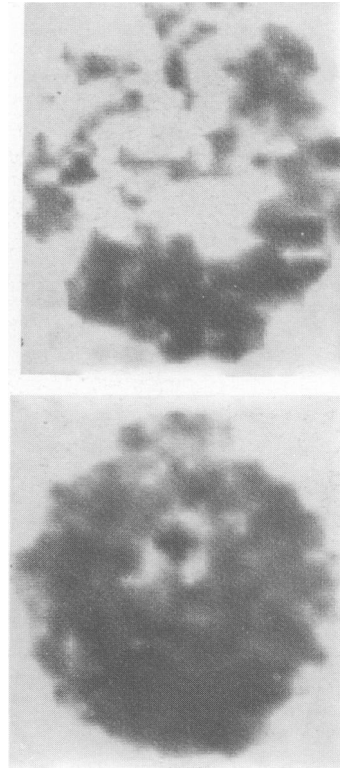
SPECT images from a schizophrenic middle-aged woman after an injection of technetium-99m HM-PAO. The scintigram at the top was acquired while she was severely disabled by classical schizophrenic symptoms such as auditory and visual hallucinations and shows very poor frontal-zone uptake (the 'hypofrontality' of schizophrenia). The scintigram below shows her in remission, when the equivalent section is indistinguishable from normal. Her medication had not changed.
